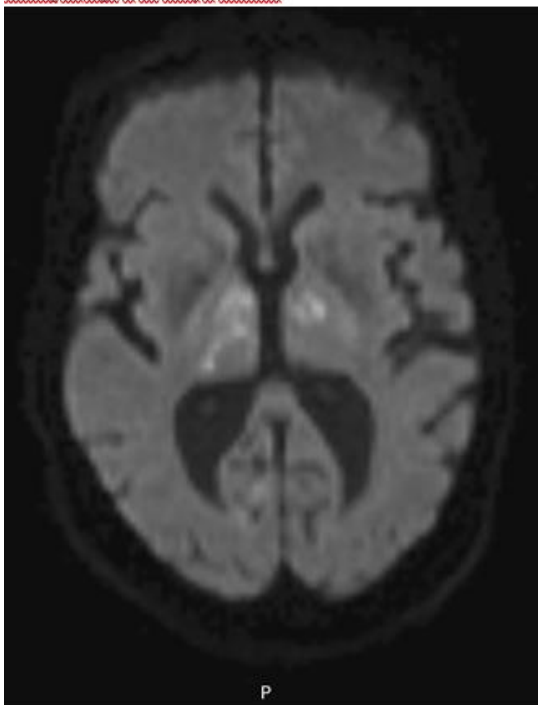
Axial diffusion-weighted MRI (DWI) showing areas of restricted diffusion consistent with acute ischemic lesions in the bilateral paramedian thalami.
